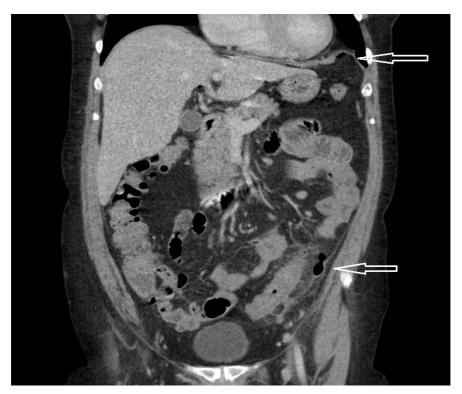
CT image of perforated acute diverticulitis with free extra-luminal air next to an inflamedsigmoid colon and in the left upper quadrant (arrows).
